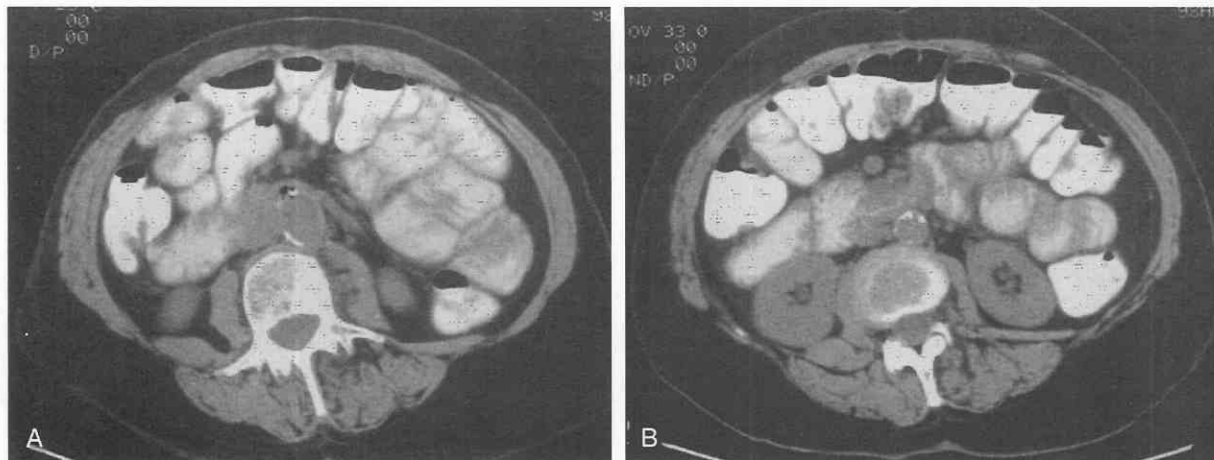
Aortoenteric fistula. *A*, Unenhanced CT scan shows a small amount of air, identified between the aortic graft and the adjacent duodenum. Distinction cannot be made between aortoenteric fistula and graft infection on the basis of this image. *B*, A slightly more cephalic scan (same patient) reveals mild thickening of the third portion of the duodenum. This finding, coupled with a history of gastrointestinal tract bleeding, suggested the correct diagnosis.
